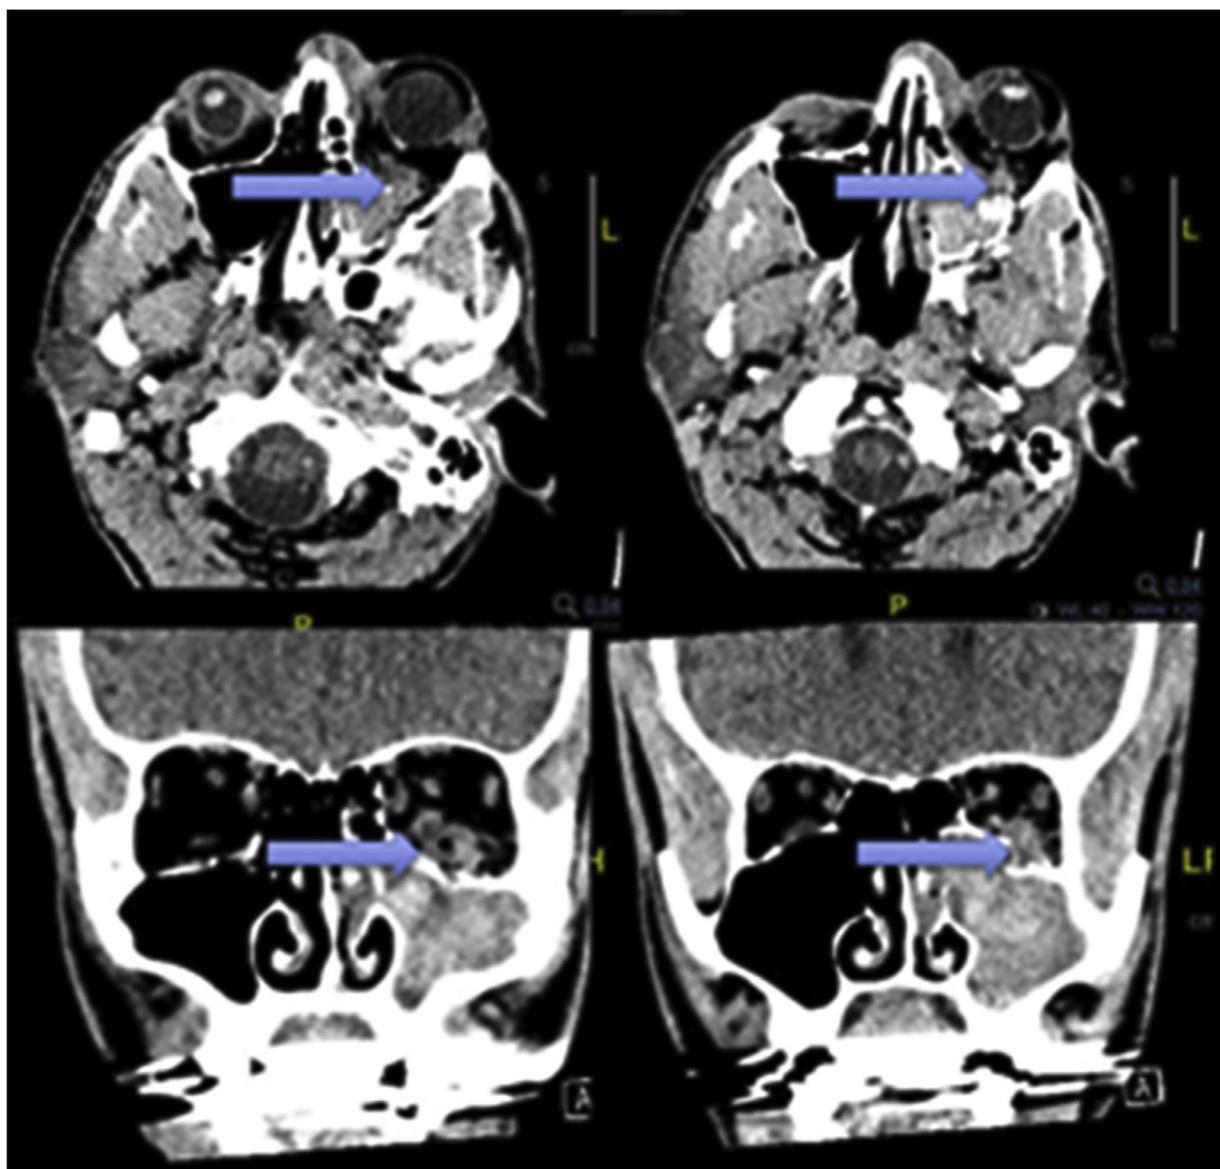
The patient lost vision in the A&E department after a bicycle accident. The surgery entailed removing part of the orbital floor (blue arrows), and full vision was restored immediately after the surgical intervention. (Computed tomographic scans; Somatom Definition AS+scanner, Siemens, Erlangen, Germany).
